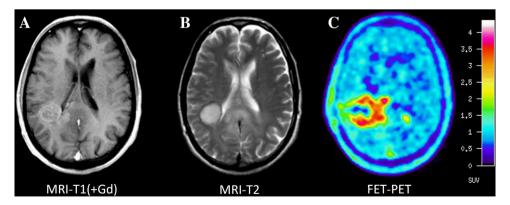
Comparison of MRI and FET PET of patient with an anaplastic astrocytoma WHO grade III. Contrast-enhanced T1-weighted MRI (A) shows pathological contrast enhancement in the vicinity of the posterior horn of the right ventricle and corresponding
